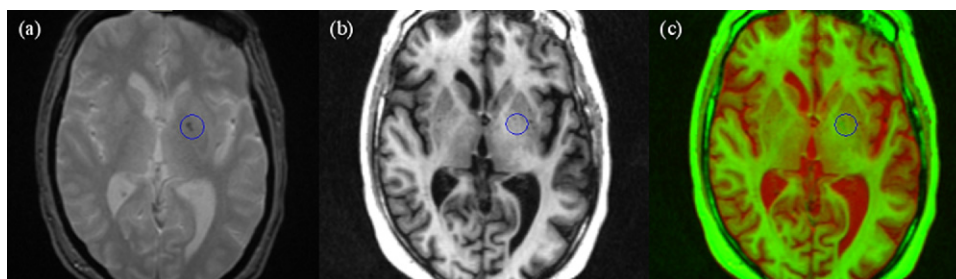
Example case with iron deposition but without calcium (circle). Axial slice showing the registration and color fusion results of (a) T2*-weighted (T2* W) and (b) T1-weighted (T1W) images. (c) The fused T2* W and T1W map does not show any color change to indicate mineral deposition (cf. Fig. 4).
